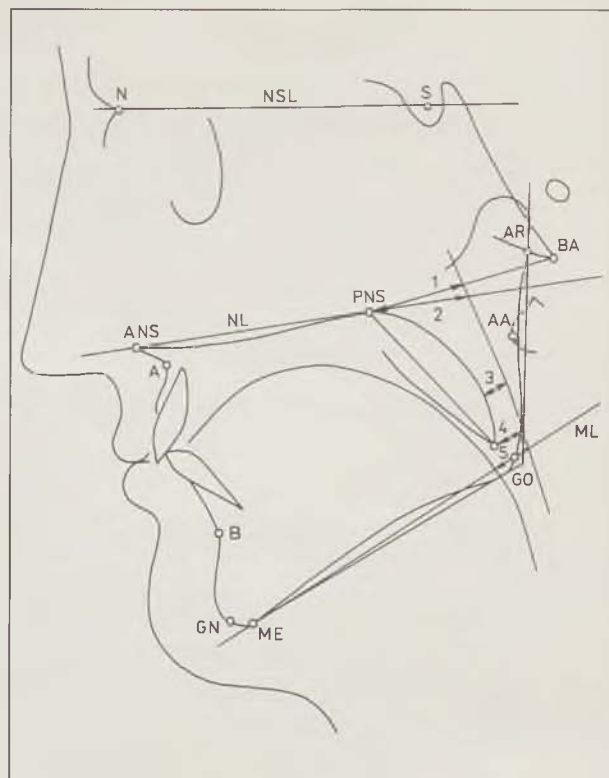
Cephalometric landmarks and reference lines used for the assessment of lateral X-ray films: A-subspinale-deepest point of the subspinal concavity, AA-anterior atlas-most anterior point of atlas, ANS-anterior nasal spine, AR-articulare-intersection of inferior contour of the cranial base and posterior contour of the ramus mandible, B-supramentale-deepest point on the anterior contour of the mandibular symphysis, BA-basion-most posteroinferior point on the clivus, GN-gnathion-most anteroinferior point of the mandibular symphysis, GO-gonion-point at the gonial angle located on the axis of the angle formed by tangents to the body and ramus of the mandible, ME-menton-lowest point of the mandibular symphysis, N-nasion-most anterior point on the frontonasal suture, PNS-posterior nasal spine, S-sella-center of sella turcica, UT-uvula tip-tip of uvula, NSL-nasion sella line, line through N and S, NL-nasal line, line through ANS and PNS, ML-mandibular line, line through ME and GO, 1. PNS-PHW1, 2. PAS(NL), 3. MinPAS, 4. PAS(UL), 5. PAS(ML)
